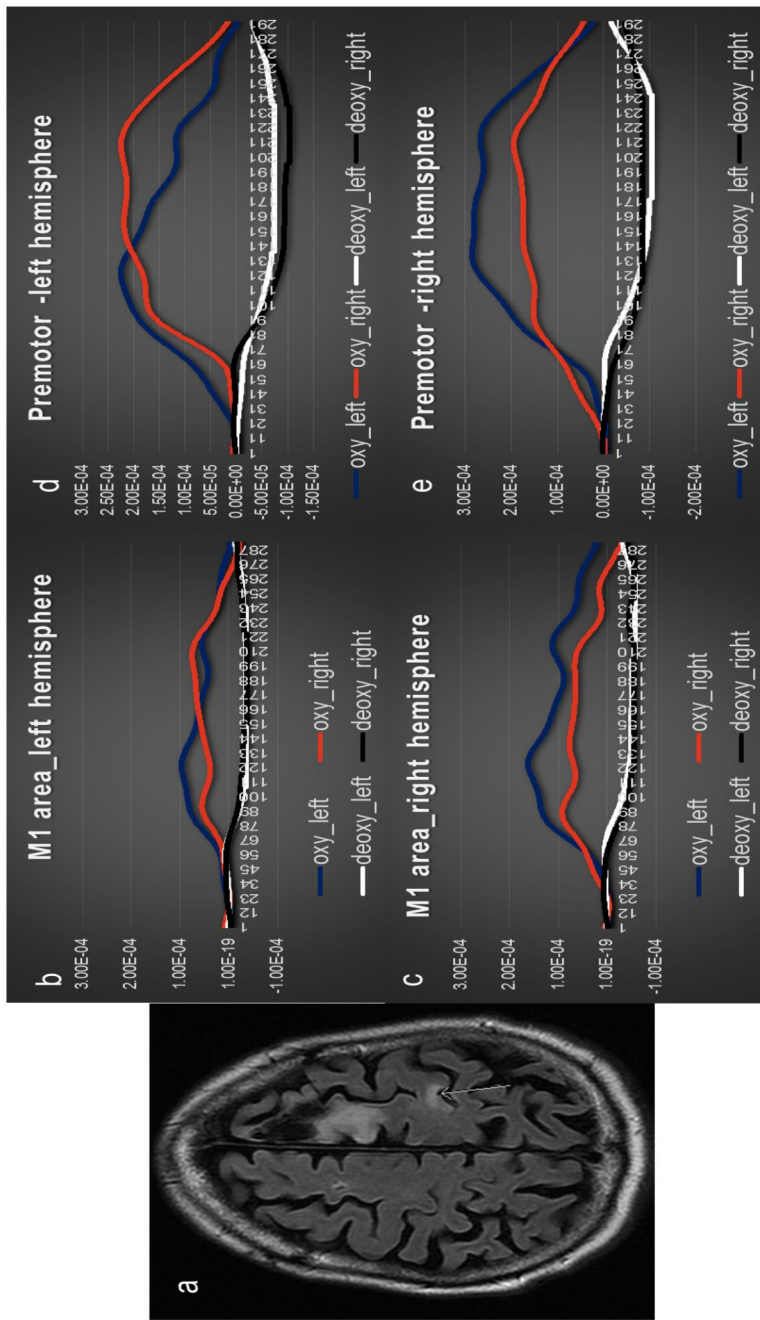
shows the MRI of the subject with left hemisphere stroke affected areas indicated in hyper intensity and arrow indicate the motor cortex b) and c) show the response from the primary motor cortex channels for both hemisphere. d) and e) show the response from the pre-motor and supplementary motor cortex channels for both hemisphere.
